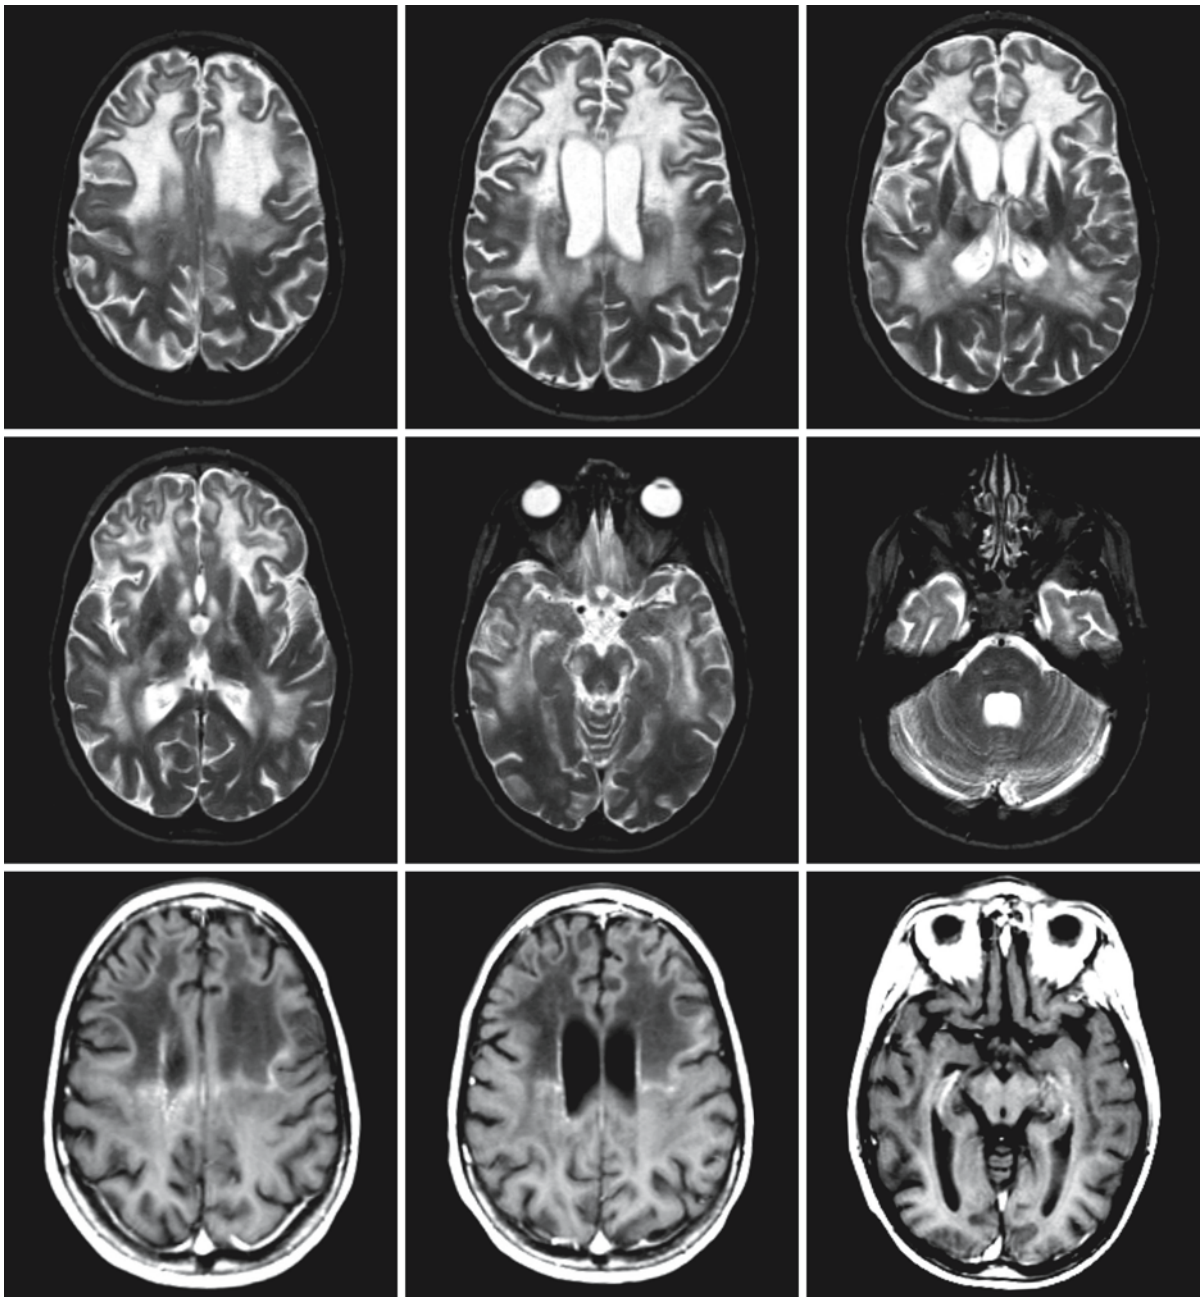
(continued). A boy with cerebral XALD. The *second three rows* show the follow-up MRI, obtained 1.5 years later. The images demonstrate serious progression of the disease
